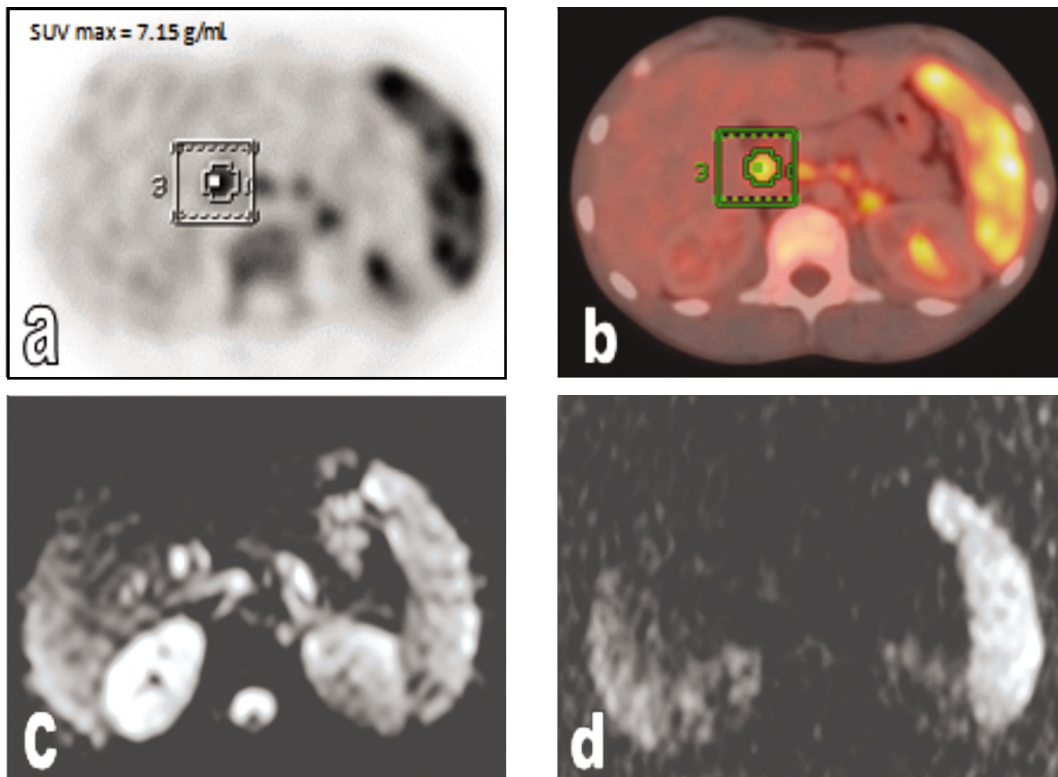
Axial PET-CT versus Axial DWIBS images for the same patient in Fig. (3): (A,B): Axial PET (A) and Fused PET-CT (B) Images demonstrating multiple metabolically active (FDG avid) abdominal (porta-hepatis, peripancreatic and para-aortic lymph nodes SUV max = 7.15g/ml. (C,D): Axial b0 DWI (a) and b1000 DWI (b). At the same levels demonstrating no definite corresponding abdominal lymph nodes detected.
